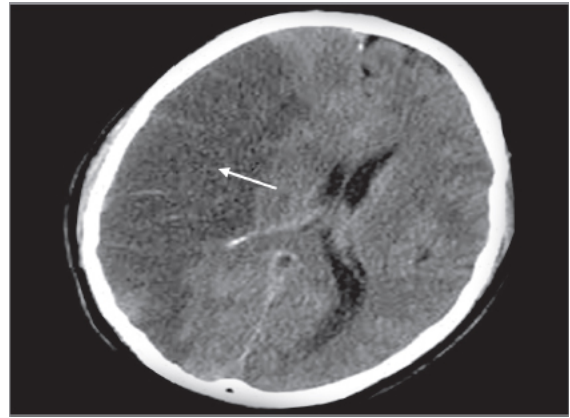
Plain CT head showing hypodense shadow in the right parietotemporal cortex suggestive of acute infarct (arrow).
